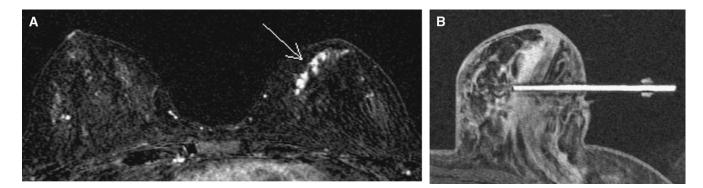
A 37-year-old woman with bloody left nipple discharge. (A) Axial contrast enhanced subtracted 2-minute T1 WI, demonstrating a linear region of nonmass enhancement at the 9-o'clock position in the left breast (arrow), suspicious for ductal carcinoma in situ (DCIS). Second-look ultrasound (not shown) only identified dilated lactiferous ducts. (B) A 10-gauge vacuum-assisted magnetic resonance imaging-guided breast biopsy at the posterior edge of the enhancement was diagnostic for intermediate grade DCIS.
